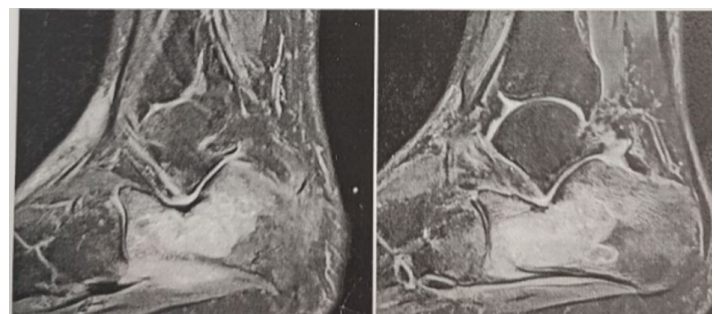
T1 and T2 weighted MRI of right ankle showing hypointense and hyperintense lesions
